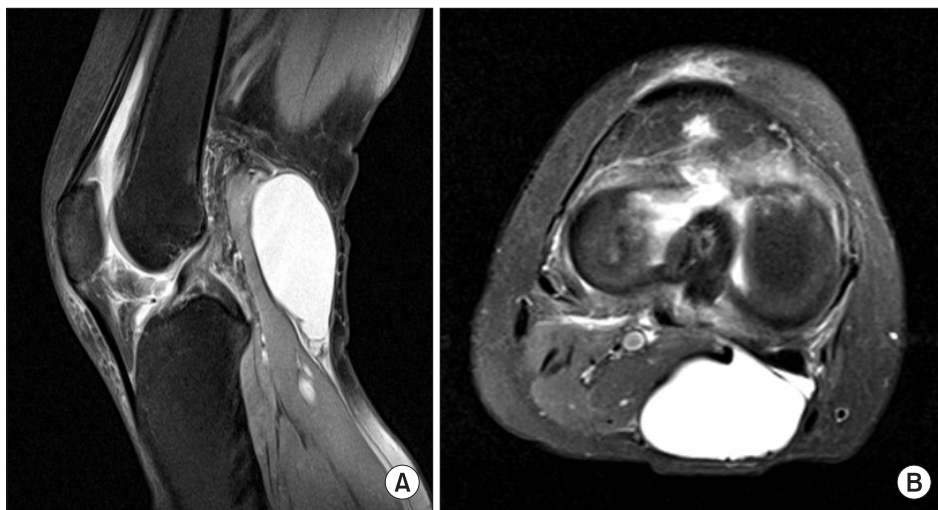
Large popliteal cyst detected in (A) sagittal T2 and (B) axial view of magnetic resonance imaging on the right knee.
